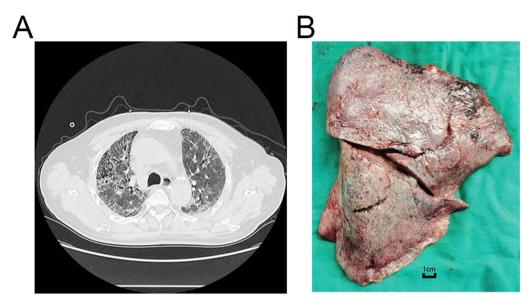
A CT scan of the recipient's lungs before lung transplantation. B The resected recipient's right lung
